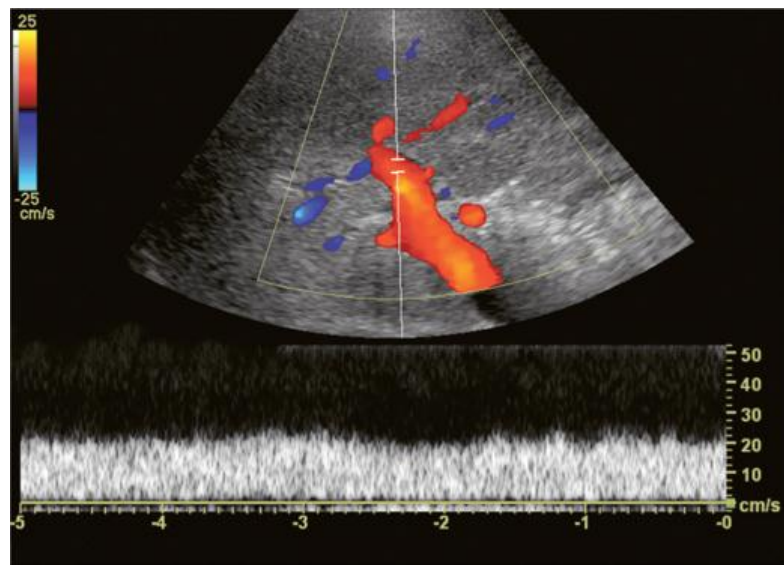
Spectral Doppler tracing of normal portal vein flow. The flow velocity of 20 cm/s is relatively uniform and in a hepatopetal direction. (Myron A Pozniak et al 2014).
